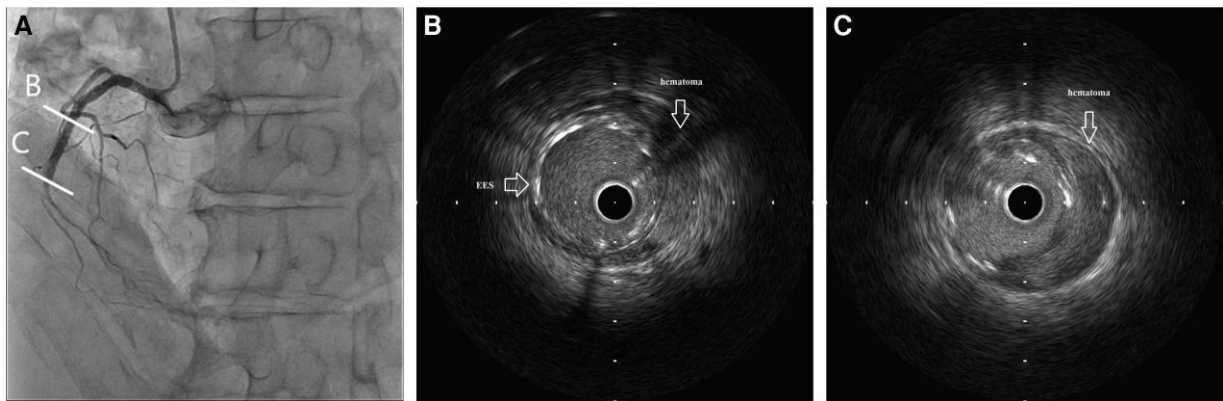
(A) Two weeks later of the first PCI, we observed severe stenosis from the distal stent edge to the distal RCA. (B and C) Intravascular ultrasound revealed a hematoma extending from the middle of the stent to the distal segment.
